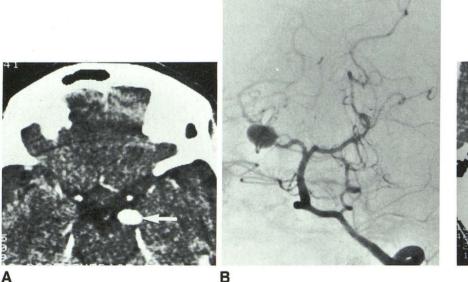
Incidental posterior cerebral artery aneurysm (arrow) at peduncular segment on contrastenhanced CT scan (A) and anteroposterior view of left vertebral angiogram (B) in patient with myasthenia gravis.
